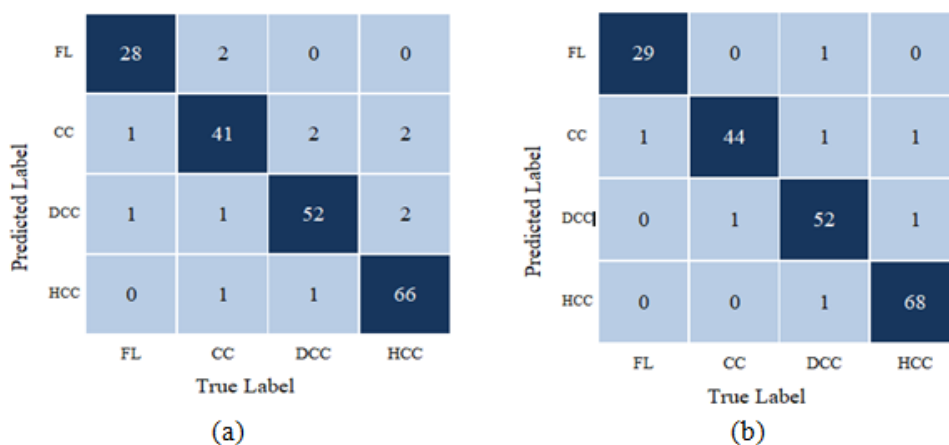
Confusion Matrix for Phase-II Classification (a)US and (b)CT images
